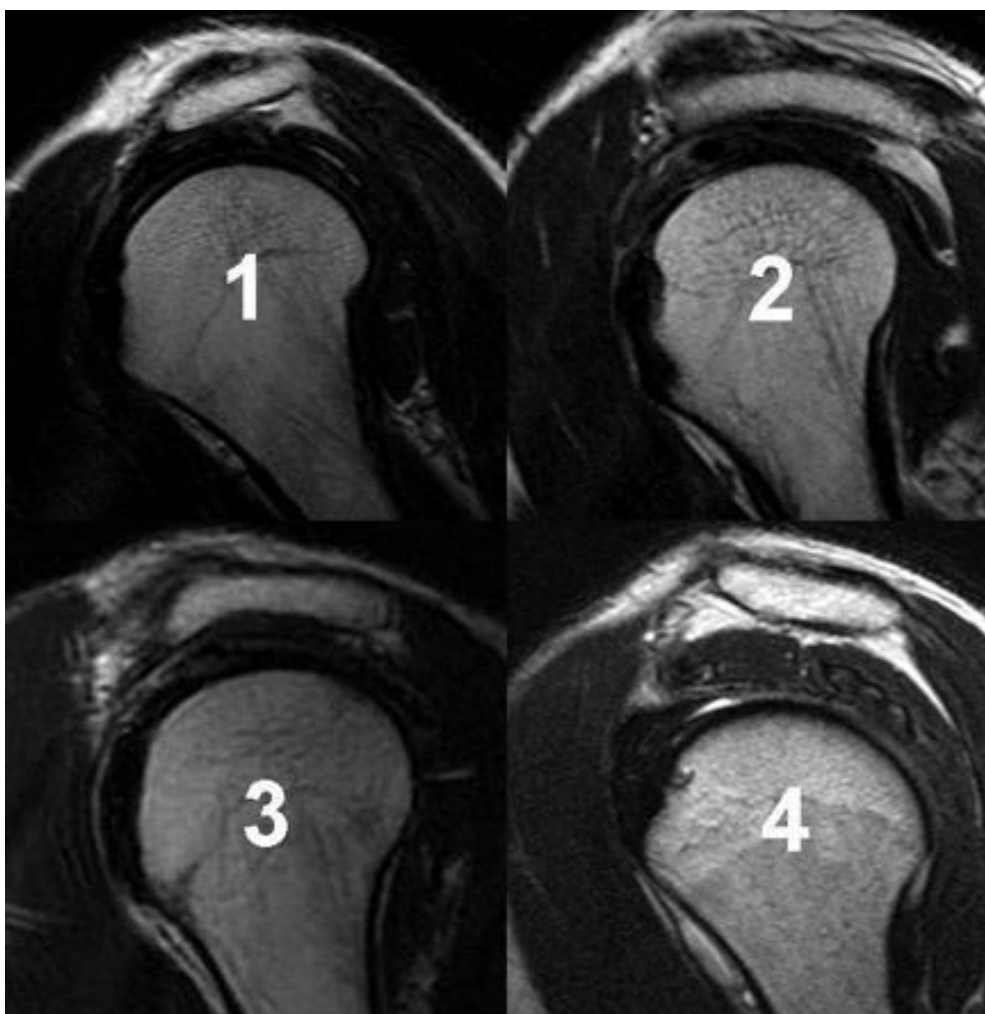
Sagittal view T2 weighted MRI of the shoulder region showing the 4 types of acromion process. 1. Flat, 2. Curved, 3. Hooked, 4. Convex.
